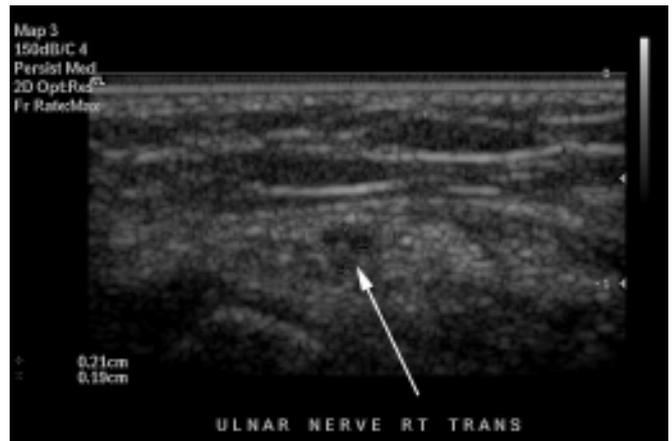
Normal transverse ultrasound appearance of the ulnar nerve, 6 months after surgery (note absence of medial epicondyle)
